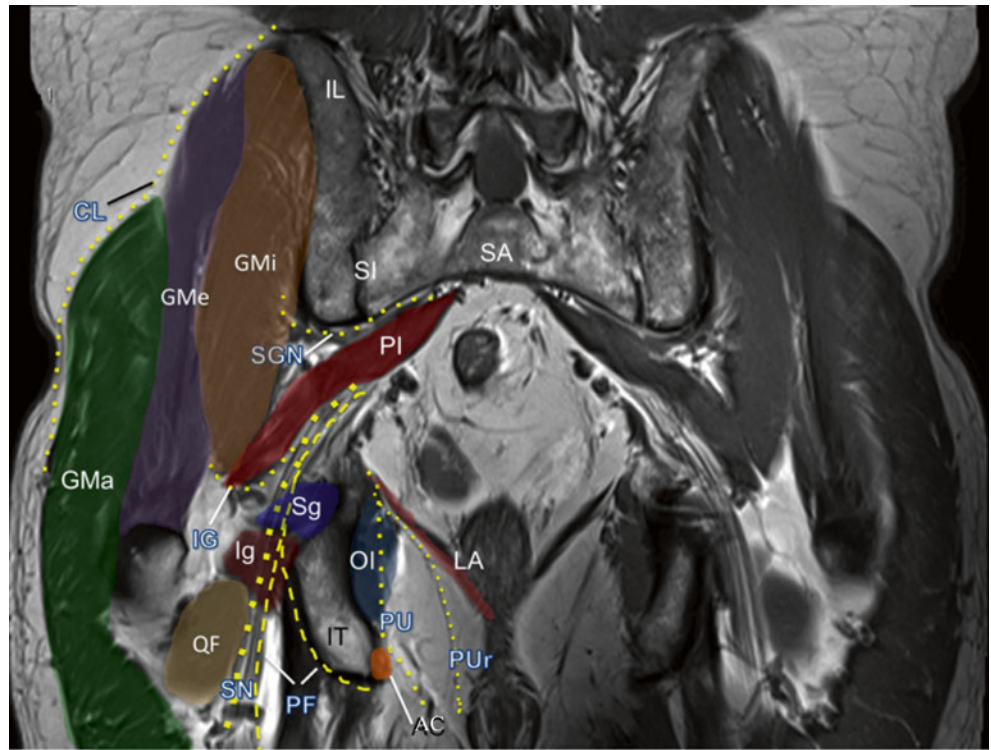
MRI coronal images showing gluteal muscles and nerves. *AC* Alcock's canal, *CL* superior cluneal nerve, *IL* iliac crest, *IG* inferior gluteal nerve, *Ig* inferior gemellus muscle, *Pi* piriformis, *Pu* pudendal, *GMi* gluteus minimus, *GMe* gluteus medius, *GMa* gluteus maximus, *GT* greater trochanter, *LA* levator ani muscle, *OI* obturator internus muscle, *PF* posterior femoral cutaneous nerve, *PU* pudendal nerve, *PUr* pudendal nerve (rectal branch), *QF* quadratus femoris muscle, *SA* sacrum, *SGN* superior gluteal nerve, *Sg* superior gemellus muscle, *SI* sacroiliac joint, *SN* sciatic nerve (Image courtesy of Andrea Trescot, MD)
